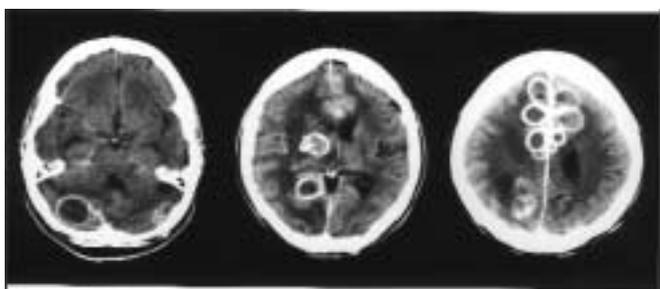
Case 1. Representative slices from contrast-enhanced CT head scan 7 weeks after presentation, at the time of onset of neurological symptoms. Multiple infra- and supra-tentorial tuberculous abscesses are present.
